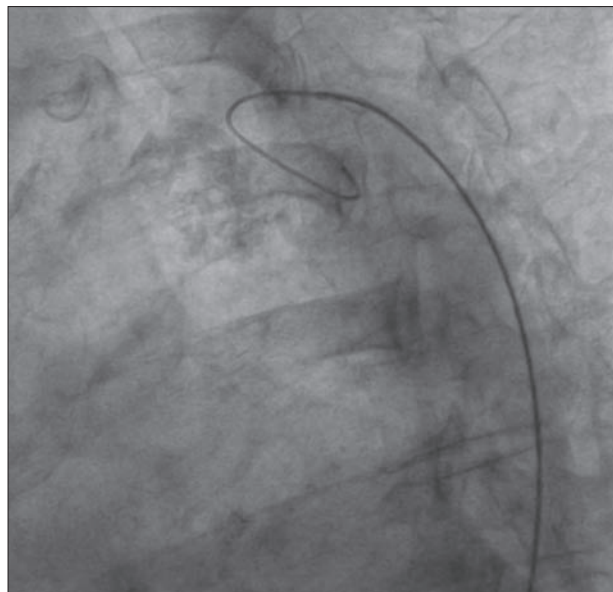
Left anterior oblique radiograph of cardiac catheterization. A J wire is seen abutting a calcified area in the aortic arch.
